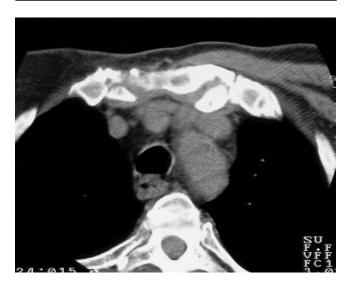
Axial CT image showing partial bony ankylosis of the left sternocostal synchondrosis and erosions of the right sterno-clavicular joints.
